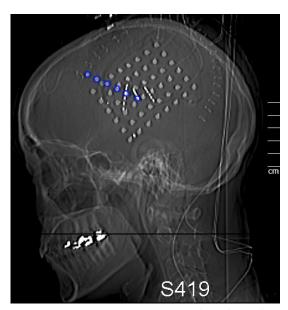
Sagital view of a patient's postoperative CT image. The intracranial electrodes can be seen as light gray dots while the extracranial electrodes are encircled in blue.
